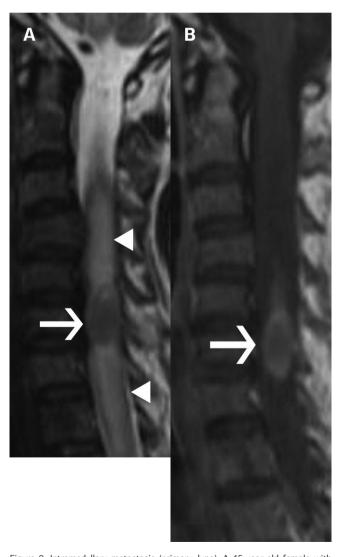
Intramedullary metastasis (primary, lung). A 45-year-old female with lung cancer with a known history of metastatic disease presents with bilateral lower and upper extremity paresthesia and weakness. On sagittal T2-weighted image (A), the intramedullary lesion appears isointense (arrow), there is a diffuse increased T2 signal, consistent with edema with enlargement of the cord (arrow head). Postcontrast sagittal (B) images show a lesion (arrow) of homogeneous enhancement in the cervical cord.
